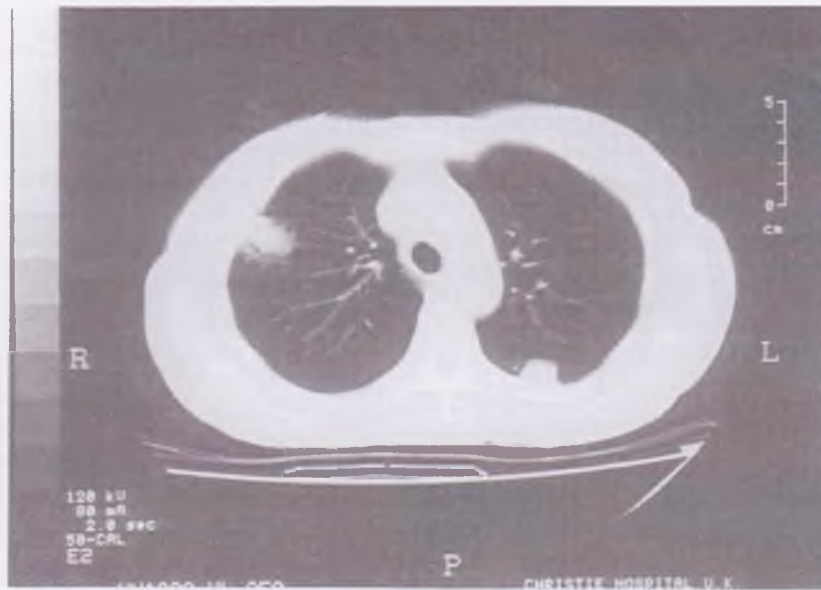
CT scan appearance of a neutropenia leukaemic patient showing a focal lesion with characteristic lower attenuation surrounding area (the "halo" sign).
